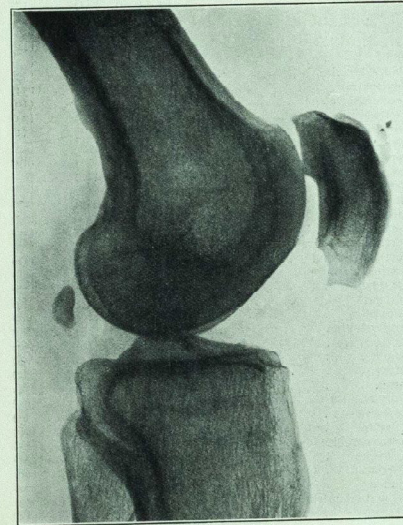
Case 20, Miss E. G.—, at. 30 years. Transverse fracture of patella repaired by fascial graft (Hey Groves' operation) May, 1928. X-ray photograph taken February, 1935. Bony union is complete. The site of fracture is only detectable by the "stepping" on the articular surface of the patella.
